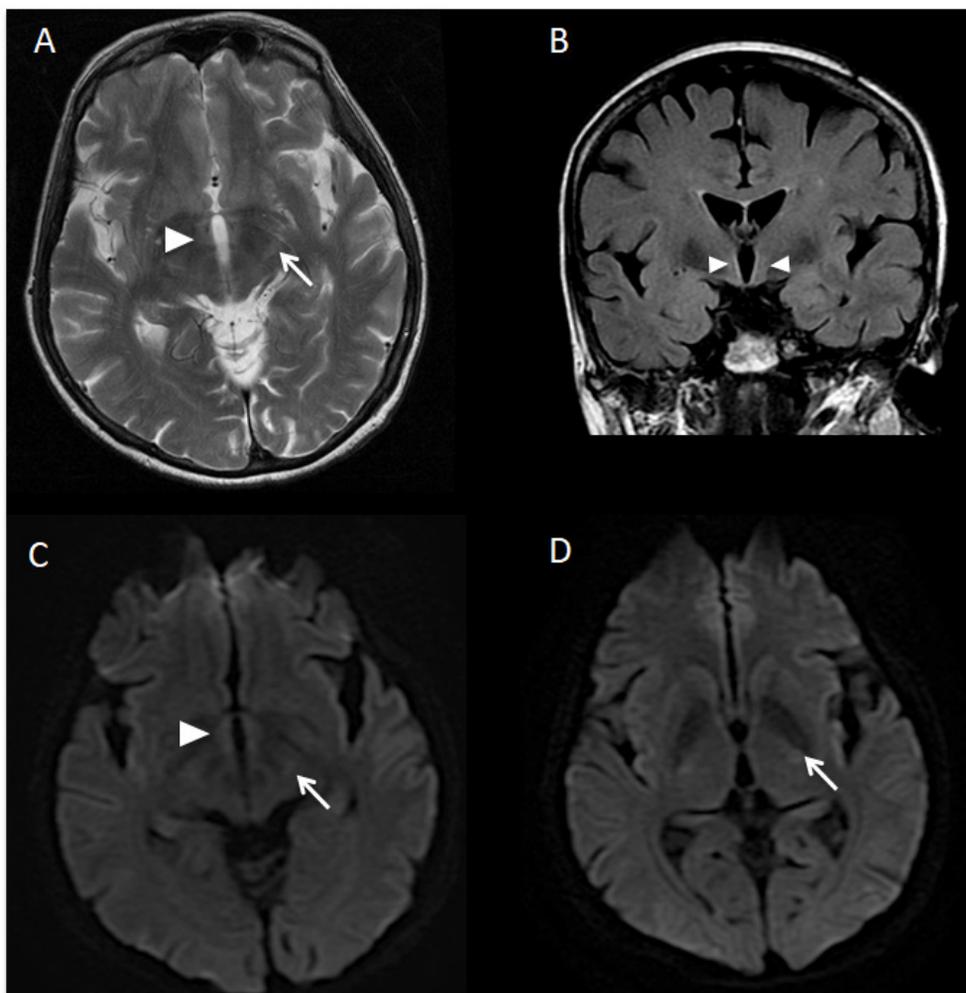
Brain MRI of Patient 2. There are bilateral symmetrical T2-weighted hyperintensities affecting the corticospinal tracts in the posterior limb of the internal capsules (PLIC) (arrow) and the hypothalamus (arrowhead) (A and B); these regions are isointense on T1 (not shown), bright on DWI (C, D) and isointense on apparent diffusion coefficient (ADC) map (not shown), indicating mild restricted diffusion. There are no signal abnormalities affecting the corticospinal tracts in the posterior centrum semiovale (not shown).
